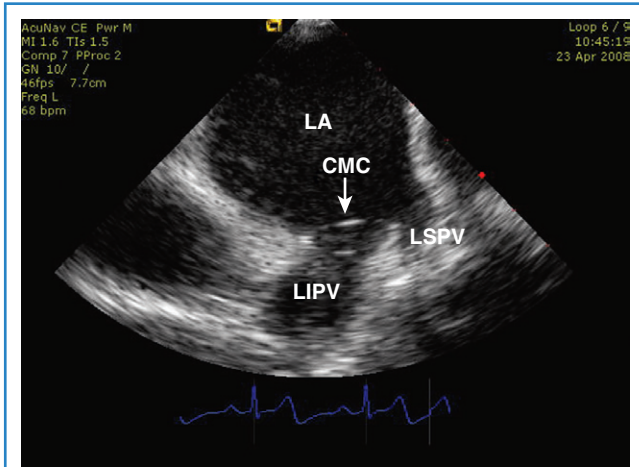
Intracardiac echocardiography image of the left atrium (LA) and left pulmonary veins demonstrating a circular mapping catheter (CMC) positioned at the antrum of the left inferior pulmonary vein (LIPV). LSPV, Left superior pulmonary vein.
